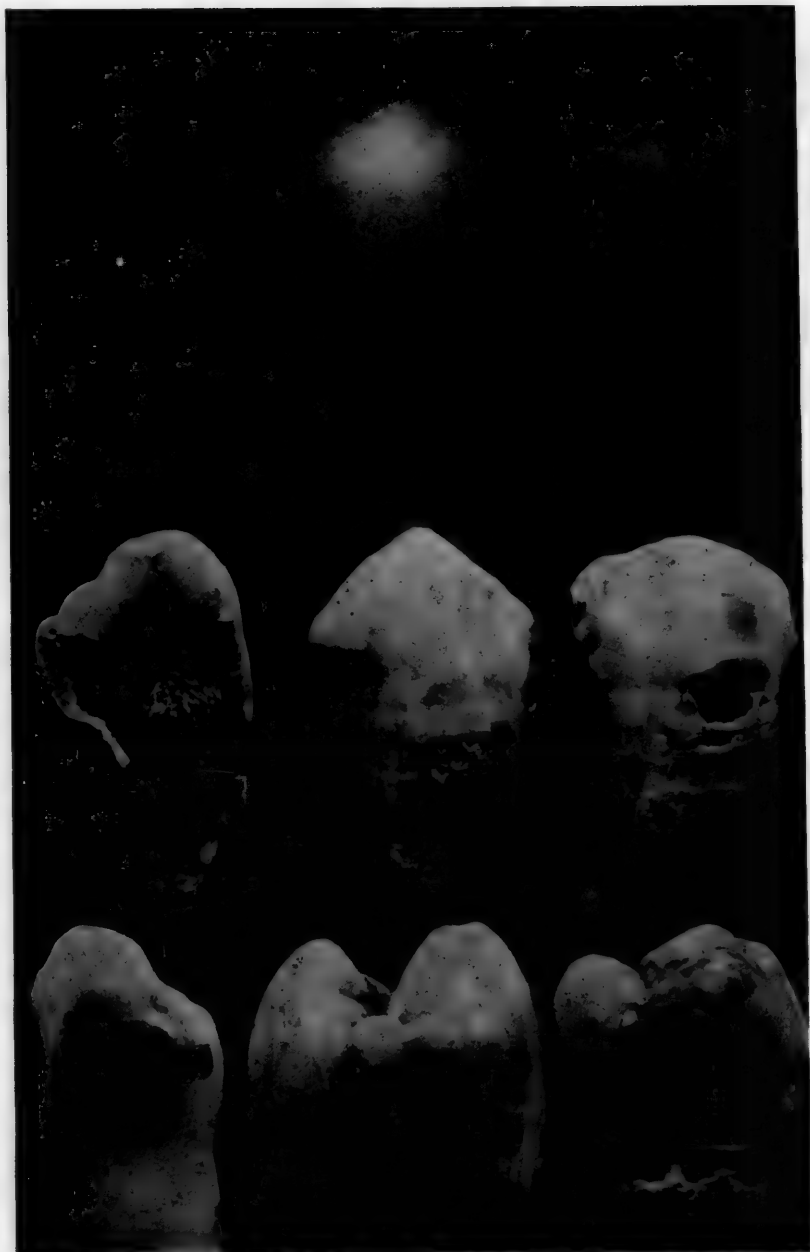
Top row shows x-ray negative of teeth at the conclusion of the experiment. (Note rarefaction on approximal surfaces.) Bottom row shows pigmentation, intact surface contour and gloss. Middle row shows buccal "lesions" in teeth B and C. The buccal region in tooth C was pierced with an explorer to show softened enamel. The buccal area in tooth C was excavated to show softened dentin and spreading at the dentinoenamel junction.
